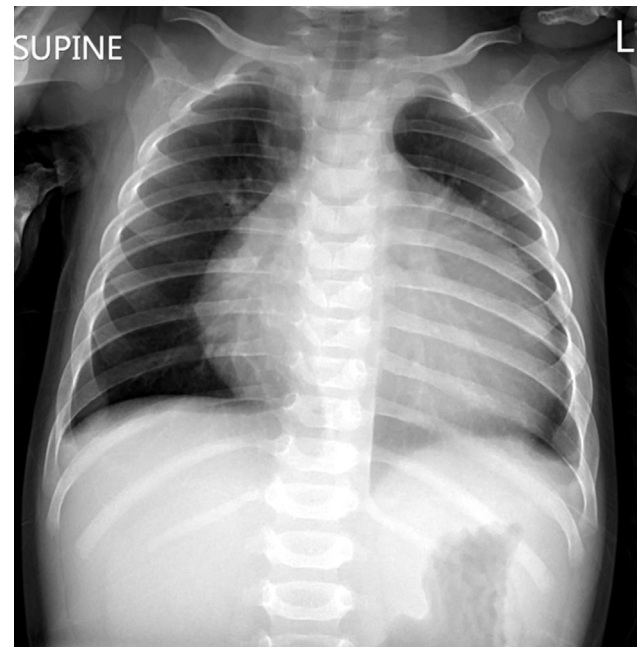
Chest x-ray reveals significant cardiomegaly.
